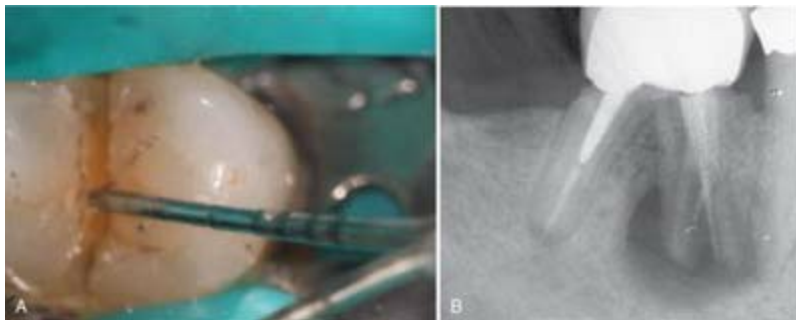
A, Observing split tooth by probing or pushing cusp. B, Radiographic evidence of split tooth.
